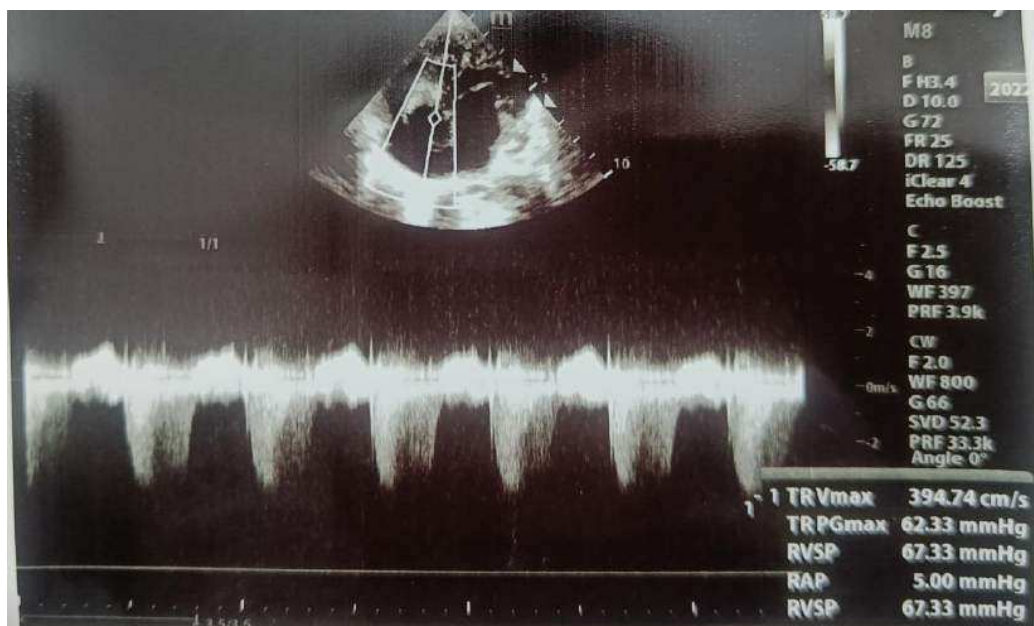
Echocardiography showing Pulmonary artery pressure is 67.33 mm Hg, signifying severe pulmonary artery hypertension.
